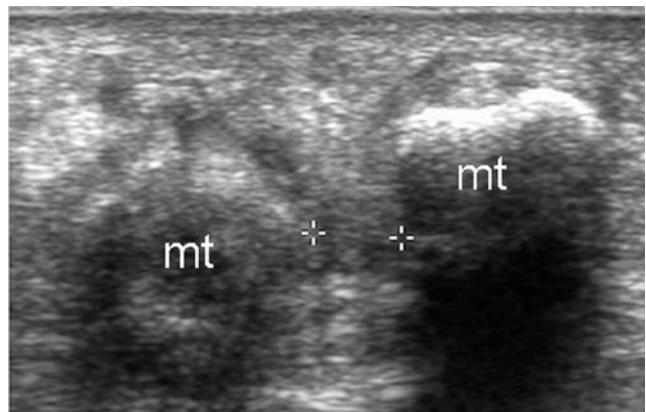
Short-axis axial ultrasound shows a 4-mm hypoechoic Morton neuroma (inside calipers) between the metatarsals (mt).
